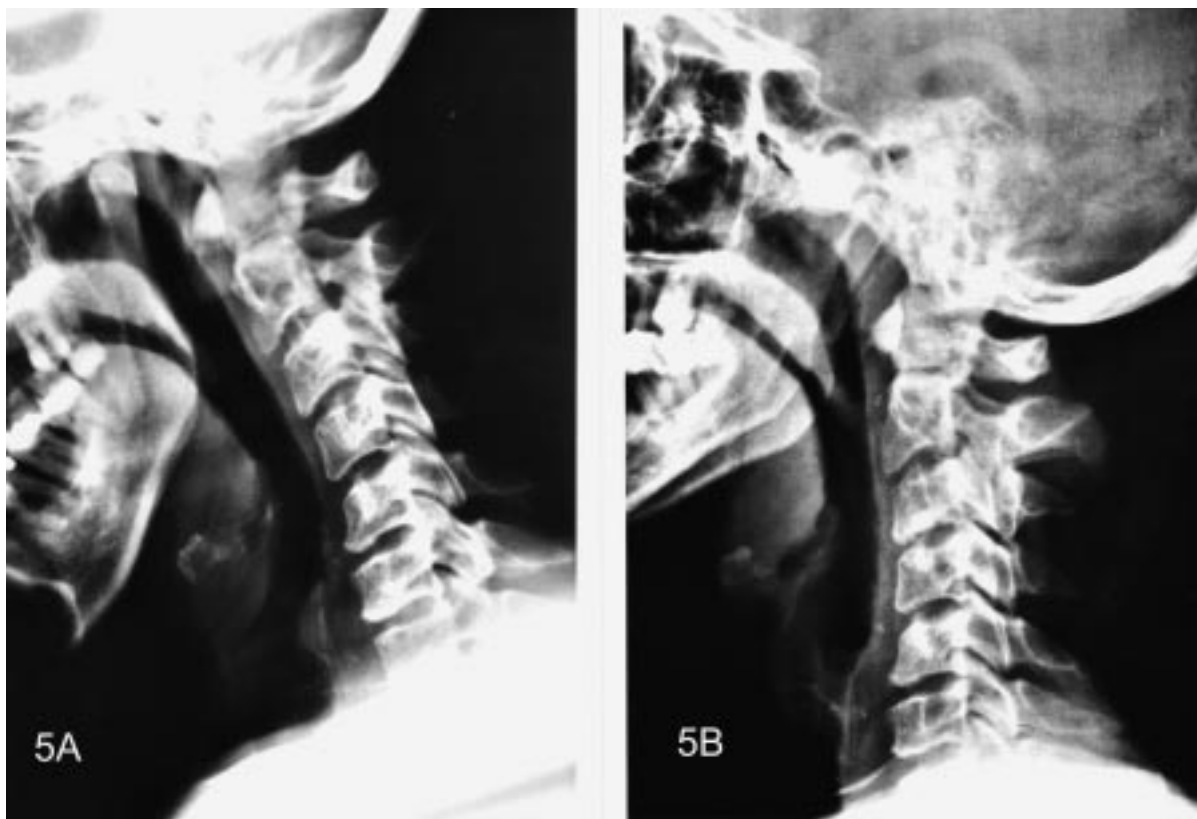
(A) Lateral flexion and (B) extension x-rays demonstrating postoperative changes and lack of motion at the C5-6 level.
